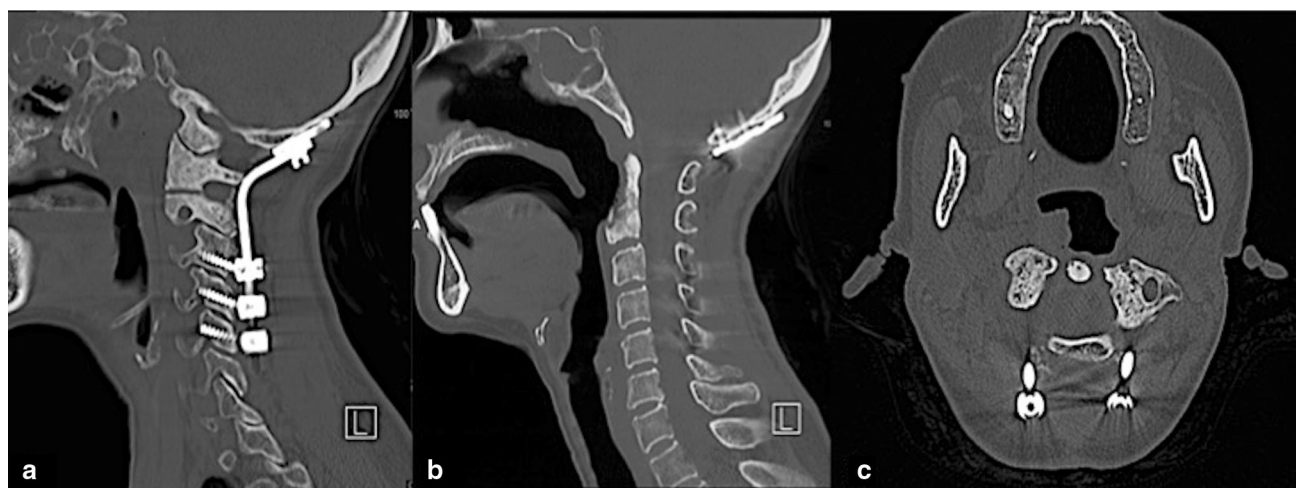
a Postoperative sagittal CT scan demonstrating satisfactory fixation and alignment after occipito-cervical fusion. b, c Postoperative sagittal and axial CT scan during the 1-year follow-up revealing
